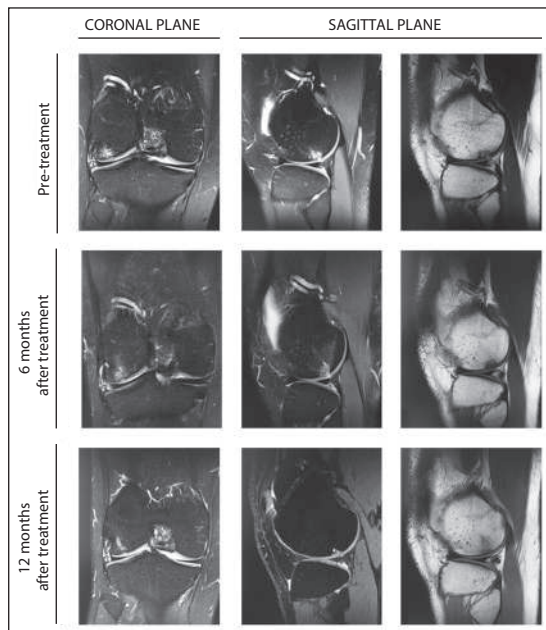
Representative MRI scans of joint status progression after Lipocell infiltration. Right knee of 18 years old patient with MRI evidences of cartilage lesion in the lateral femoral condyle before the surgery, improved at 6 and 12 months. Left and central sequences are T1-weighted; right sequences are T2-weighted.
